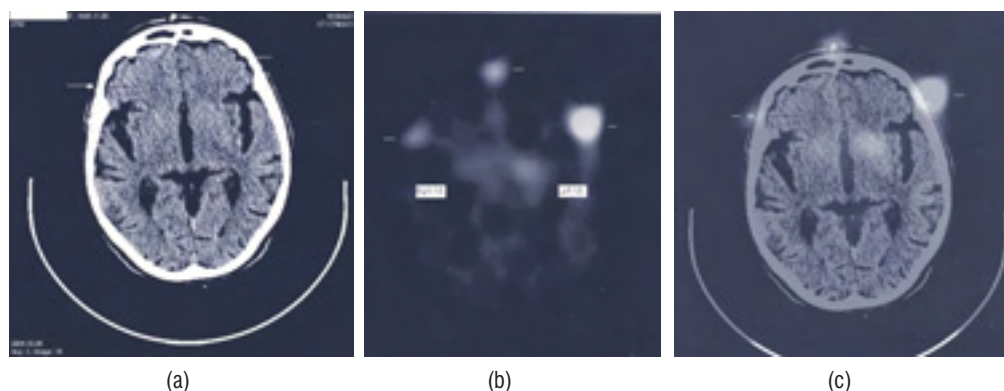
Patient No 12 with mild TRAP symptoms on the right lateral view. SPET ^{123}I -ioflupane showed an asymmetric NS area image with decreased uptake of the tracer in the left side: RNS/Occ=2.841, LNS/Occ=1.601 and PDANS/NNS=0.65. Clinical and scintigraphic diagnosis of PD with loss of DAT transporters in the left NS area
